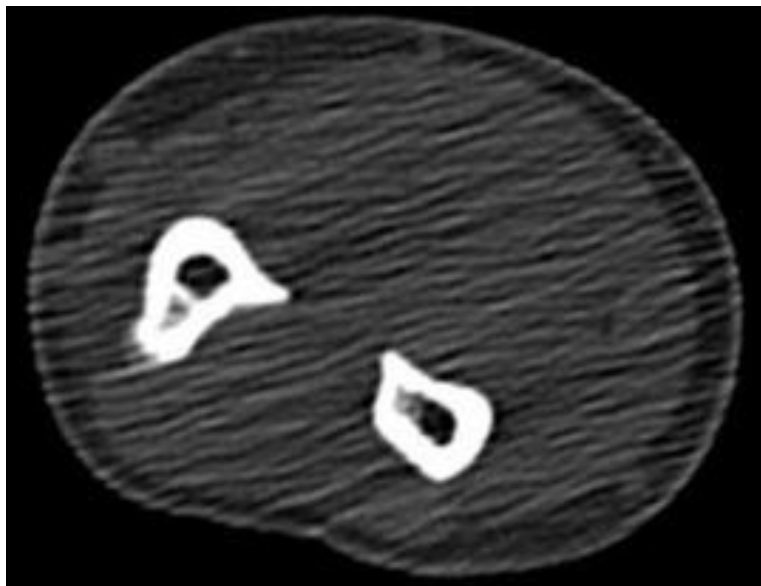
Axial view CT scan of the right forearm showing a clearly defined nidus with a hill-like protuberance.
